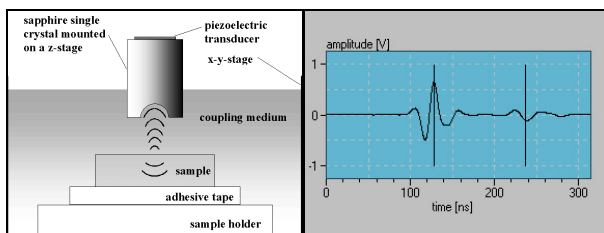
left, the SAM setup; right, measurement of ultrasonic wave velocity: the first signal stems from the upper, the second from the lower surface reflection.
